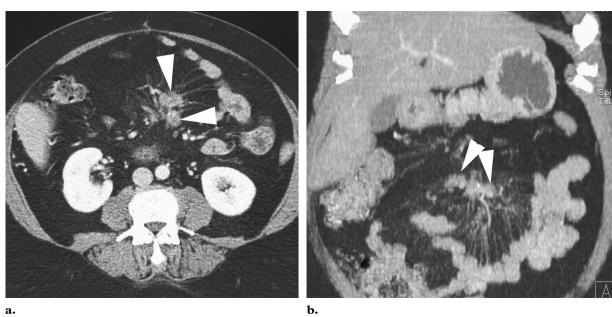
Sclerosing mesenteritis. Axial CT scan (a) and coronal multiplanar reformatted image (b) demonstrate irregular soft-tissue masses in the root of the mesentery (arrowheads).
